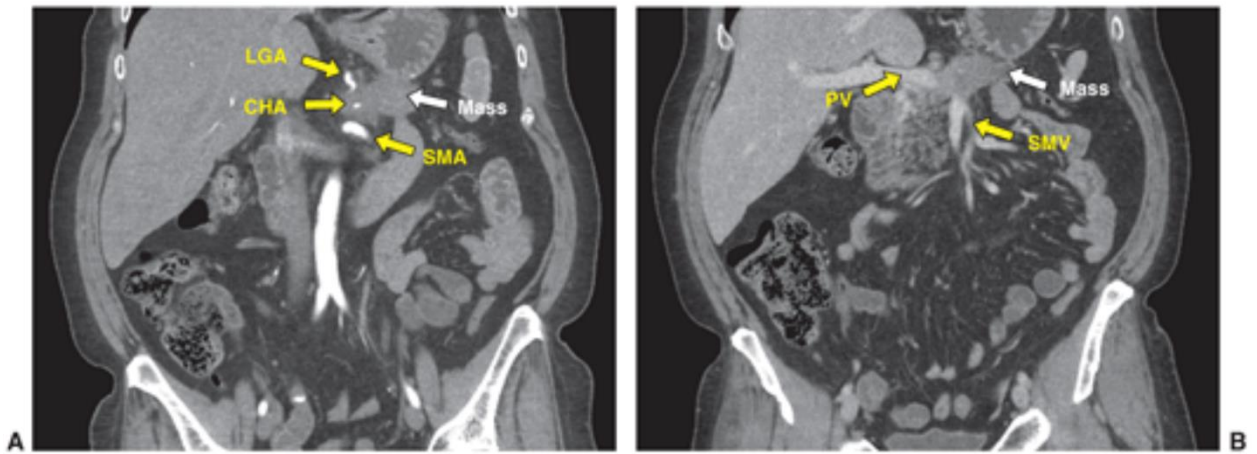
CT scan of a locally advanced stage 3 carcinoma of pancreatic body. Coronal images, (A) The arterial phase. Visceral arteries named are left gastric artery (LGA). Common hepatic artery (CHA). And superior mesenteric artery (SMA). (B) The venous phase. the portal splenic confluence is completely occluded.
